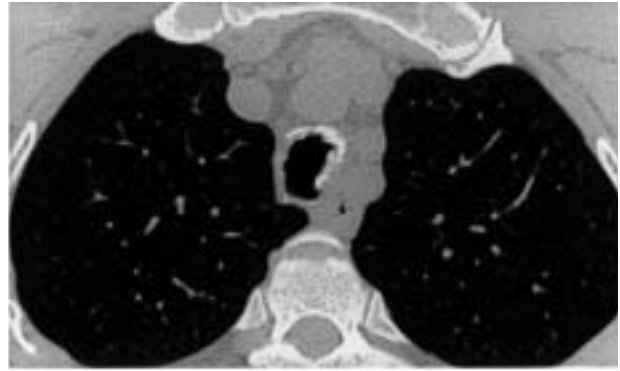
Computed tomography (CT) scan, at the level of the trachea.
